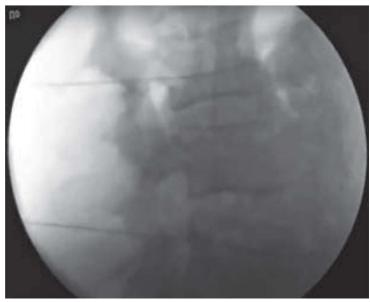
X-ray guided (lateral projection) needle placement for chemical lumbar sympathectomy
